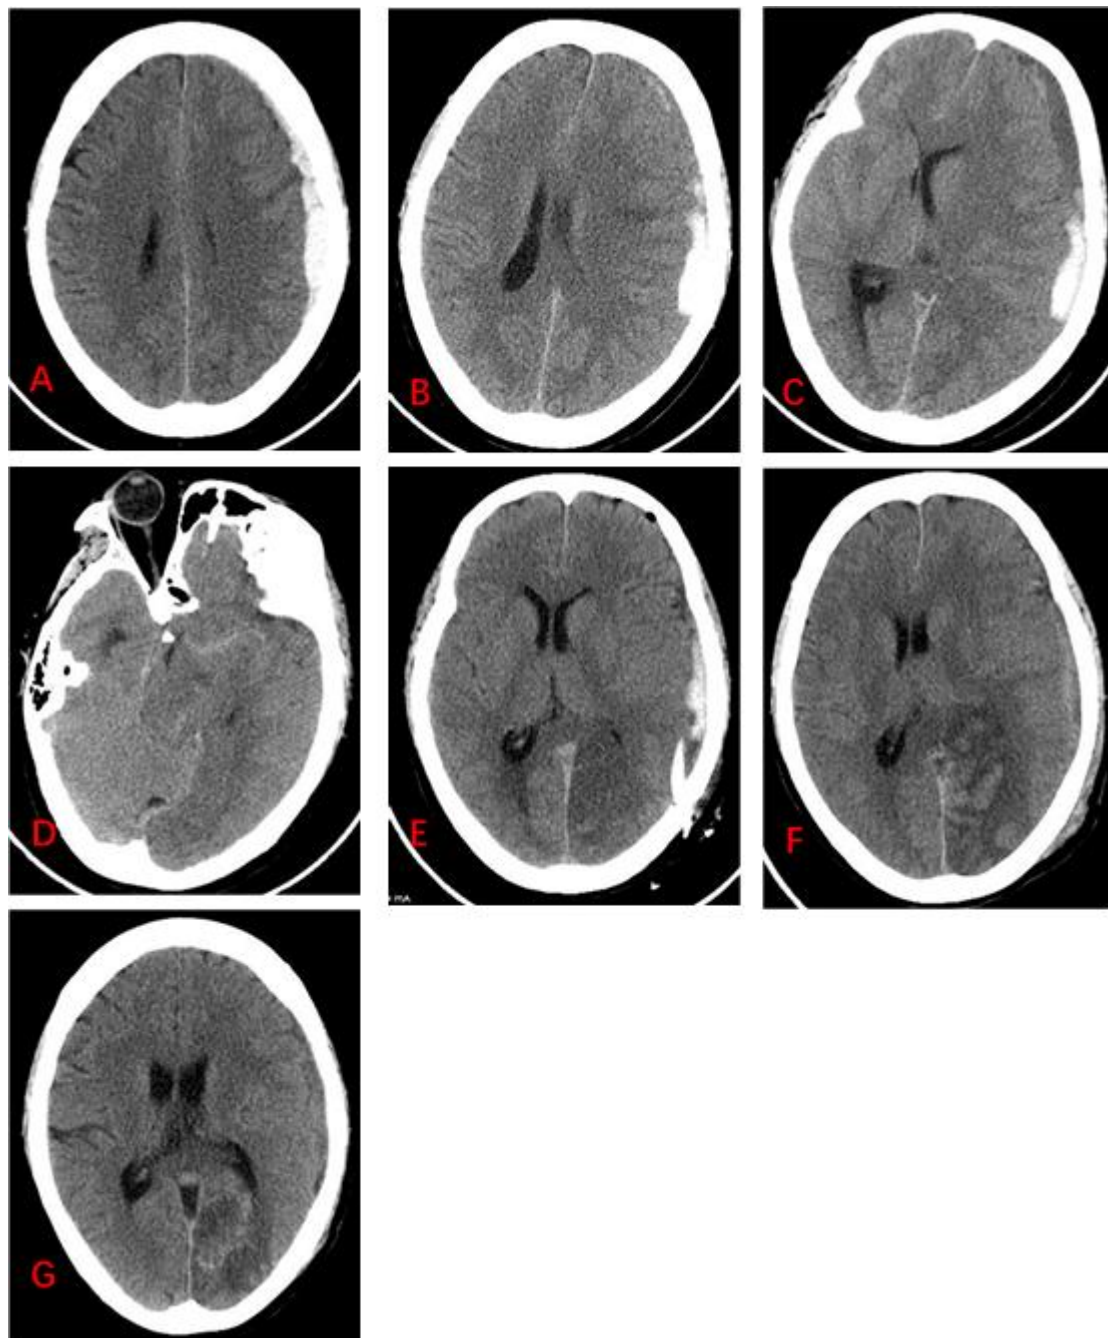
Serial Computed Tomography (CT) scans. A) Initial CT after Traumatic Brain Injury (TBI) showed an acute Subdural Hematoma (SDH) in the left hemisphere with 4 mm Midline Shift (MLS). B) CT 7 days after TBI revealed a left acute-on-subacute SDH with 8 mm MLS. C, D) CT 9 days after TBI demonstrated expansion of the acute-on-subacute SDH with 15 mm MLS, cerebral infarction in the left posterior cerebral artery territory and descending tentorial herniation. E) CT 2 hours after burr-hole drainage showed subacute SDH removed and improvement in MLS. F) CT 2 days after burr-hole drainage demonstrated Hemorrhagic Transformation (HT) without mass effect in left occipital lobe infarction. G) CT 1 week after HT revealed significant reduction of SDH and MLS but existence of hypertensity in infarct area.
